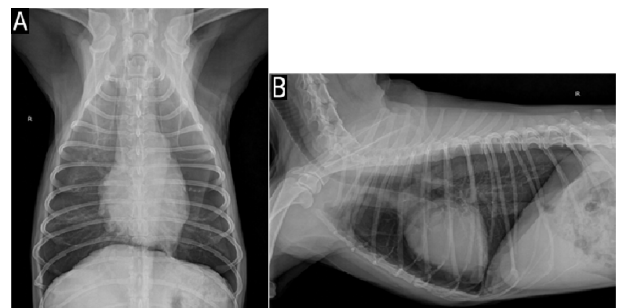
Survey thoracic radiographs show pneumothorax characterized by radiolucent area, retracted lung lobes, and decreased volume of the left cranial lung lobe on ventrodorsal (A) and lateral (B) views.
